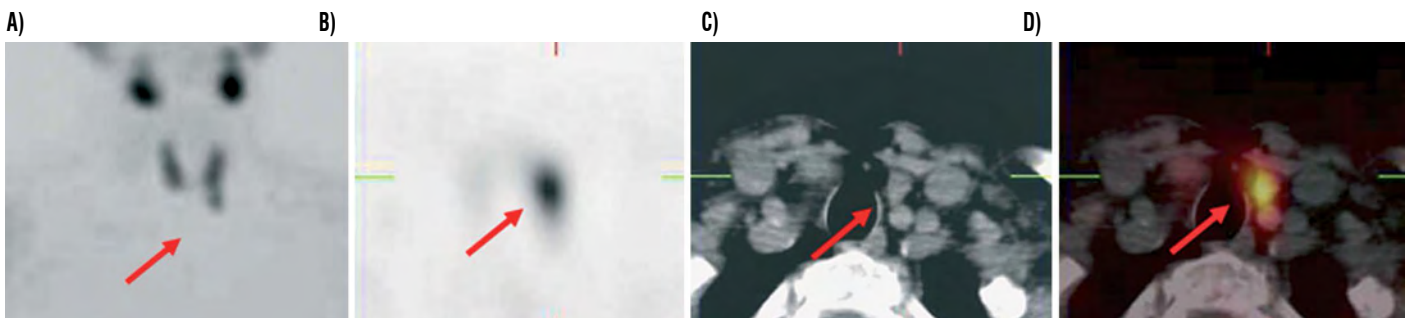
99mTc sesta MIBI SPECT/CT: parathyroid adenoma behind the lower pole of the right thyroid lobe (arrow). Accurate localisation is mandatory if minimally invasive radioguided surgery is planned. (A) MIT, (B) SPECT, (C) CT, (D) Fusion image
